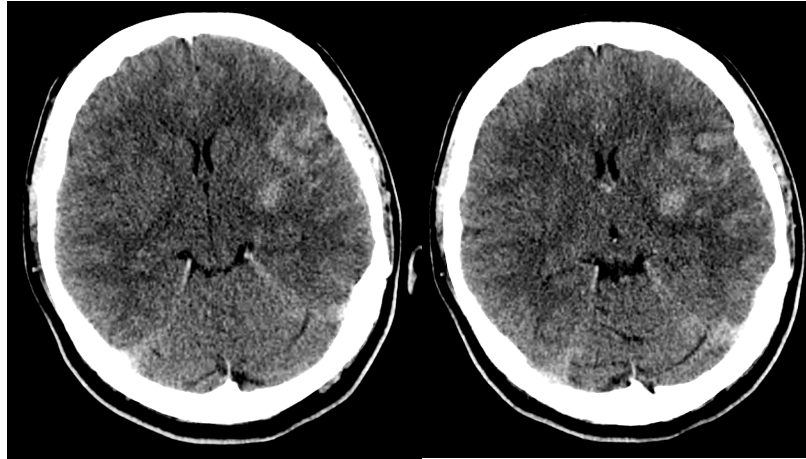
Non-contrast CT scan of 43-year old female with a left frontoparietal middle cerebral artery stroke. The multifocal higher density areas are regions of petechial haemorrhage.
